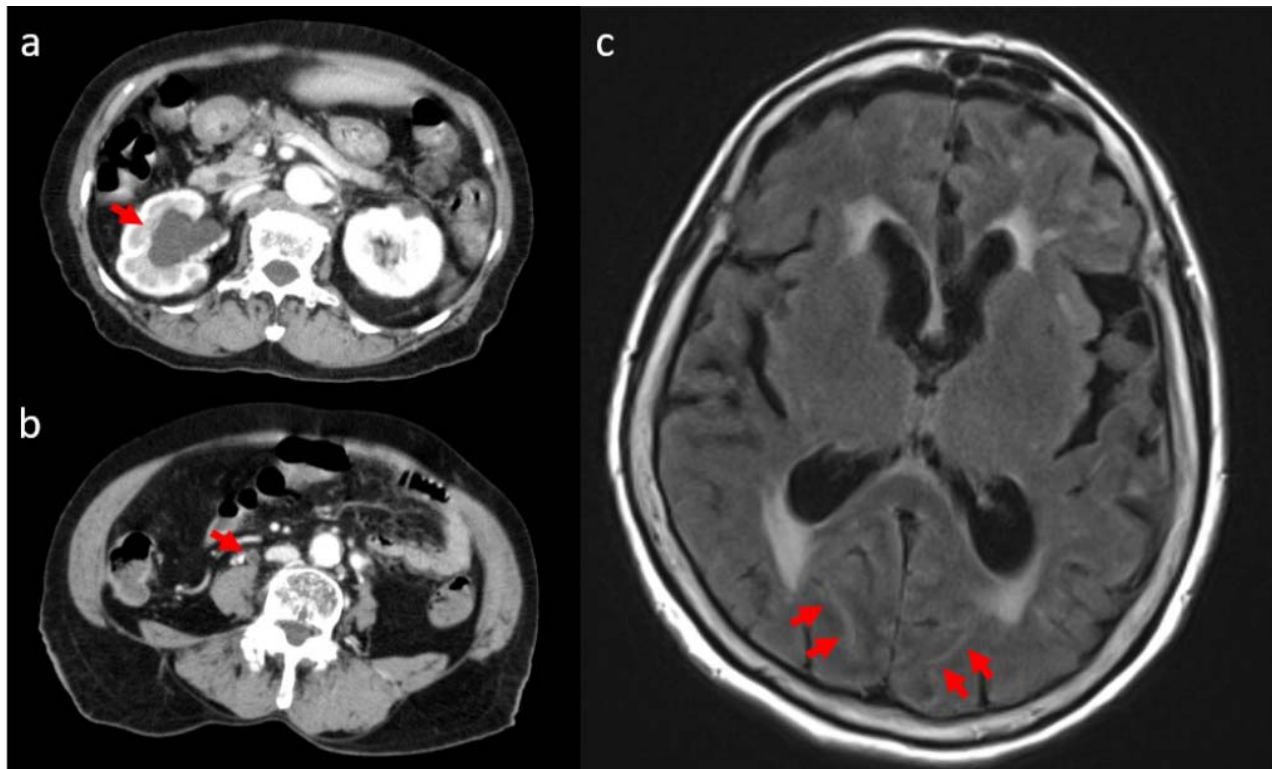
Imaging findings. (a, b) Computed tomography shows hydronephrosis in the right kidney (arrow in a) and ureteral thickening (arrow in b). (c) Magnetic resonance imaging of the brain shows hyperintense areas of lesions along the cerebral sulci (arrows).
